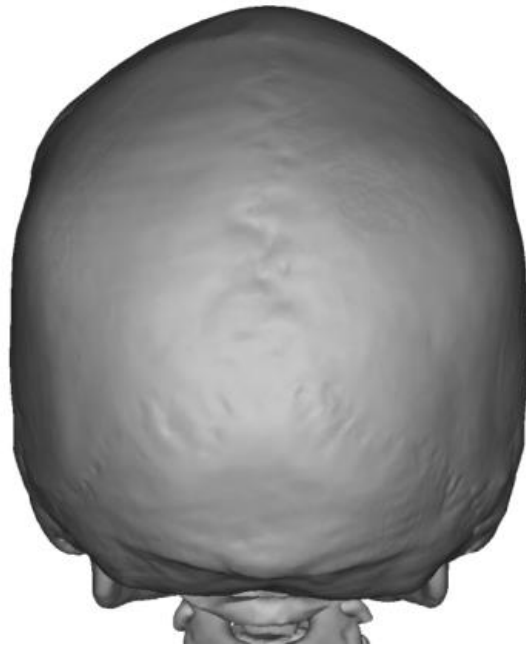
3D segmentation of the skull of a 24- year-old female generated from CT scans performed with a Siemens Somatom Sensation 4, 120kV, 200mAs, 3mm slice thickness and 2.5 mm slice increment.
